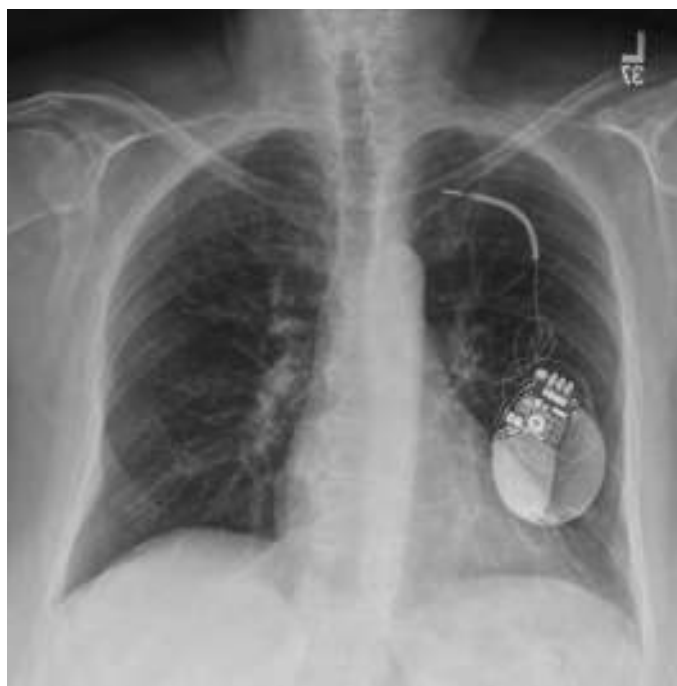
Chest radiograph of a patient with Twiddler syndrome. (Photo used with permission from reference 77.)
